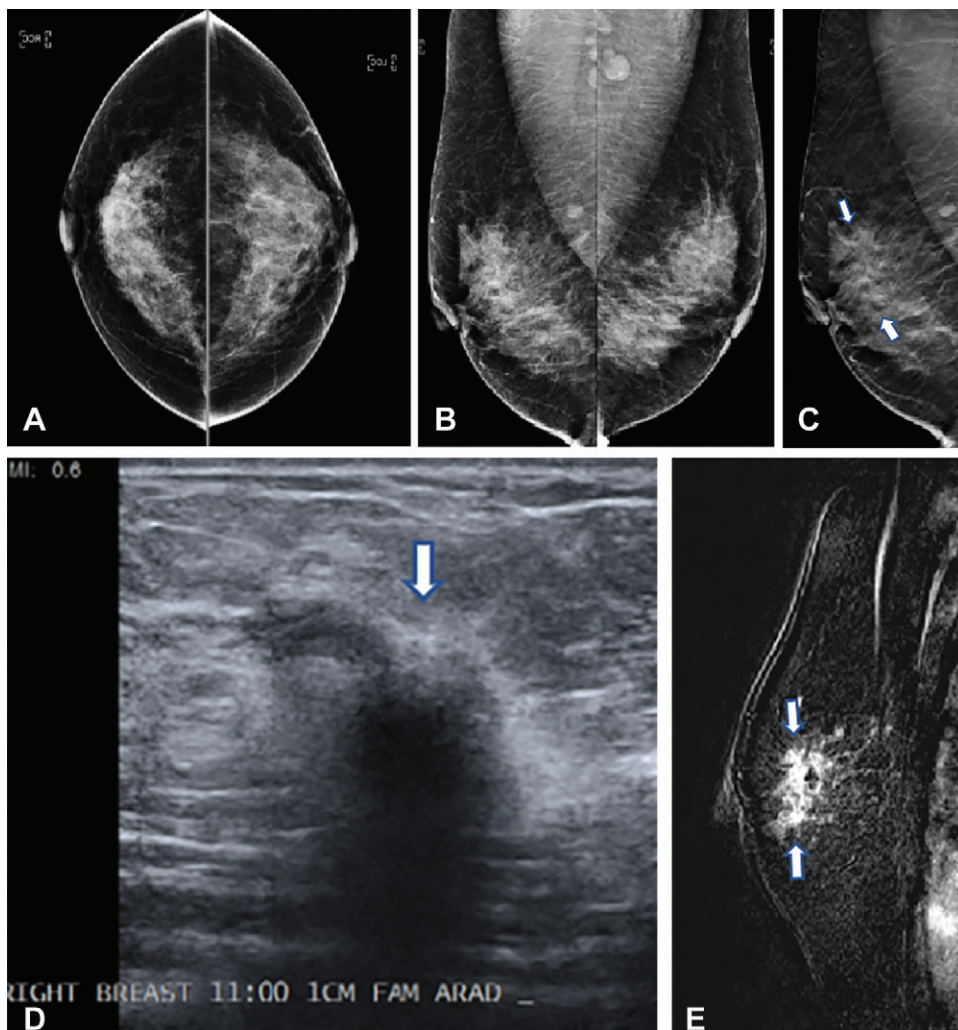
Images in a 42-year-old woman who presented for routine screening. (A) Two-dimensional craniocaudal digital mammogram and (B) two-dimensional mediolateral digital mammogram show heterogeneously dense breast tissue with no abnormality. (C) Mediolateral digital breast tomosynthesis image shows subtle architectural distortion (arrows) extending superiorly from the nipple level. (D) Target US image of the right breast shows a highly suspicious, hypoechoic, irregular mass (arrow). US-guided core biopsy yielded invasive ductal carcinoma with extensive ductal carcinoma in situ (T2N0M0; estrogen receptor–positive, progesterone receptor–positive, and human epidermal growth factor receptor 2–negative). (E) Right-breast MRI scan acquired to evaluate the extent of disease shows a clip artifact in the superior aspect of the irregular enhancing mass (arrows). No other suspicious lesions were seen.
